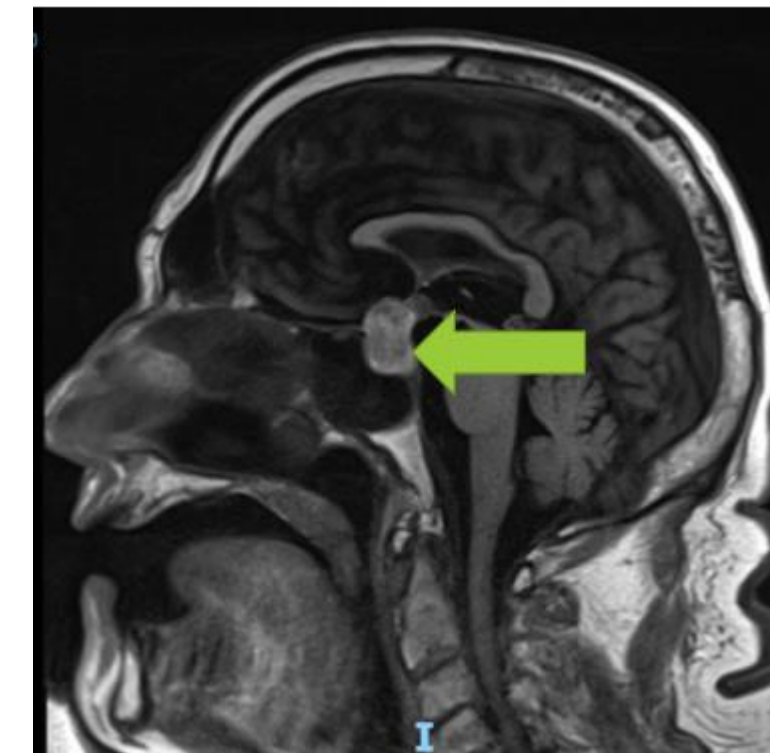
MRI brain obtained on hospital day (HD) 2 showing a stable pituitary adenoma, measuring 2.3 cm, causing mass effect on the optic apparatus.
